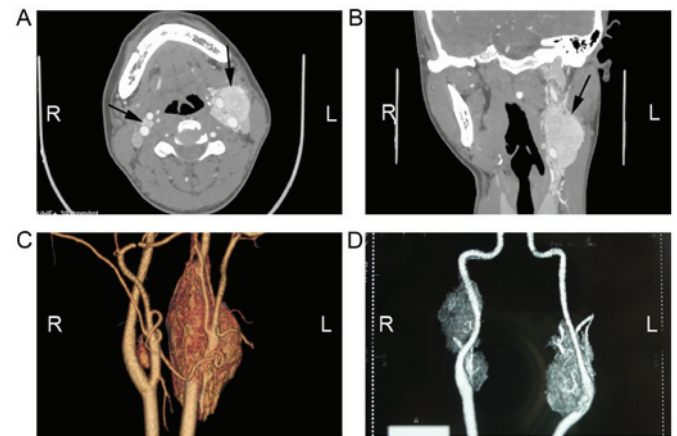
CT images. (A) Enhanced CT scan, plain image. (B) Enhanced CT scan, coronal scan image. (C) Three-dimensional imaging demonstrating bilateral CBT. (D) An additional bilateral CBT; however, the patient abandoned treatment. CT, computed tomography; CBT, carotid body tumor.
